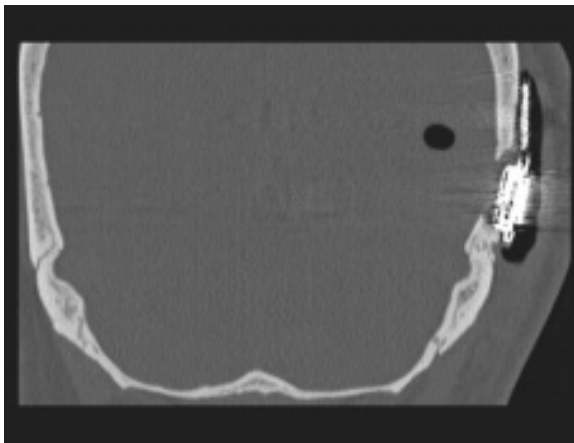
High-resolution CT scan coronal cut showing the cochlear implant, extracranial soft tissue free air as well as intra-parenchymal pneumocephalus.
